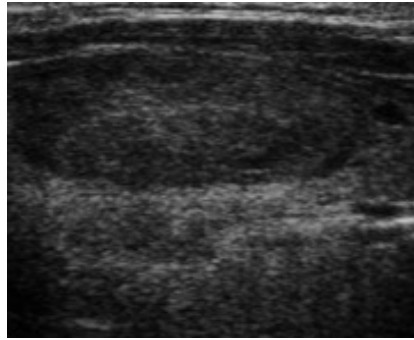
Sonographic Appearances predominantly Hypo Echoic Lesion with Isoechoic Areas
